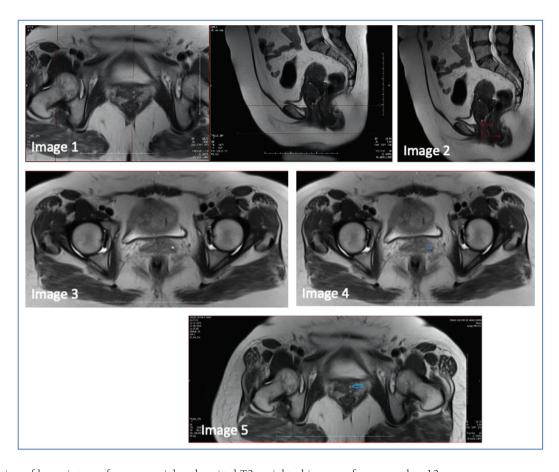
Localization of hyperintense focus on axial and sagittal T2-weighted images of case number 13
